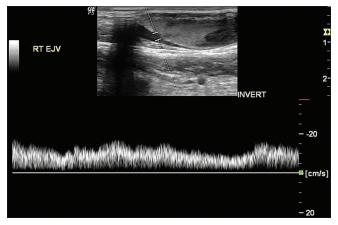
Spectral Doppler analysis showed venous waveform
